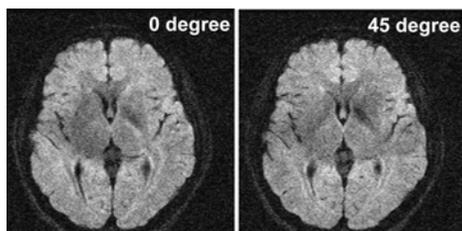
Isotropic SS-DWI with diffusion gradients along A/P and L/R direction and diffusion gradients along the LA/RP and LP/RA ( $45^\circ$  rotated)
